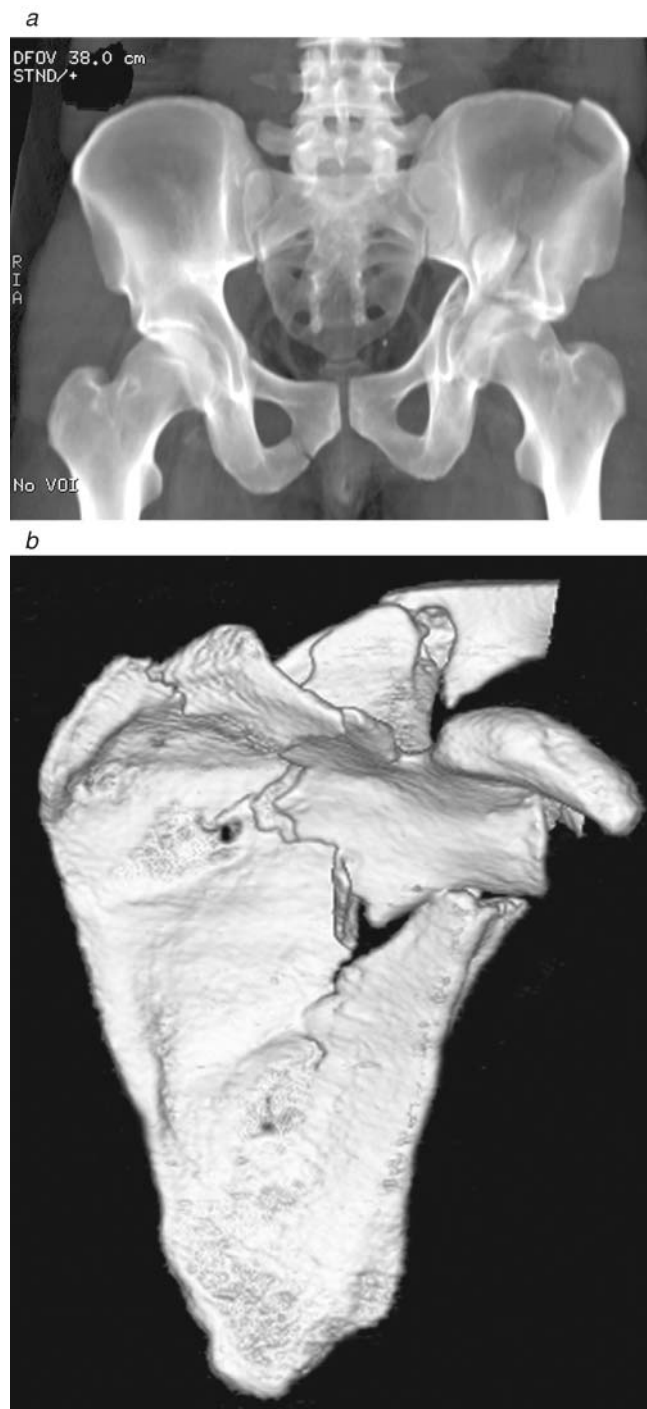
(a) Volume-rendered transmission display image of the pelvis processed to provide an appearance similar to that of a pelvic radiograph. Note that the iliac portions of the sacroiliac joints can be visualized through the sacrum, similar to the effect seen with a radiograph. (b) Volume-rendered surface display image of the scapula, visualized from the front. Note that we cannot see through the scapula, and objects posterior to the visualized portion of the scapula are invisible on this view.
